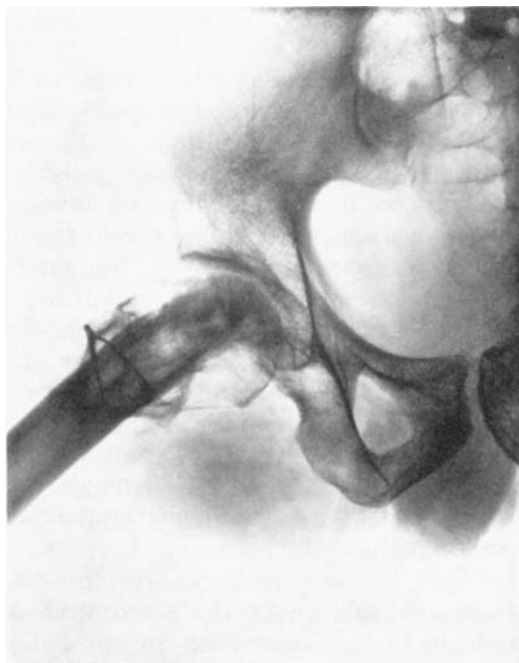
d. Axial radiograph taken 18 years after operation. In this direction the shape of the head is very good.
